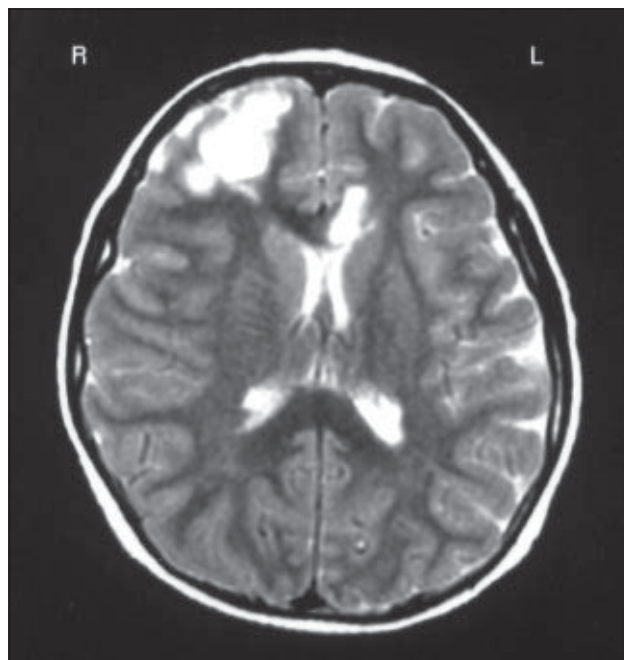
Axial T2-weighted image shows multiple hyperintense lesions in the right frontal lobe. A small high signal lesion is also noted at the left genu of the corpus callosum
